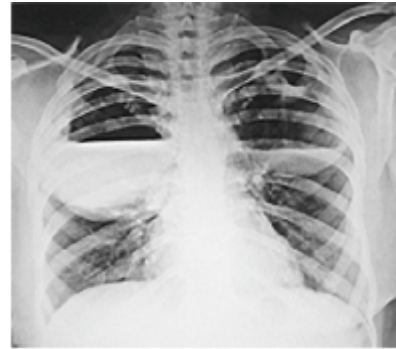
X-Ray Showing Increase in Cavity Size despite Empirical Therapy
